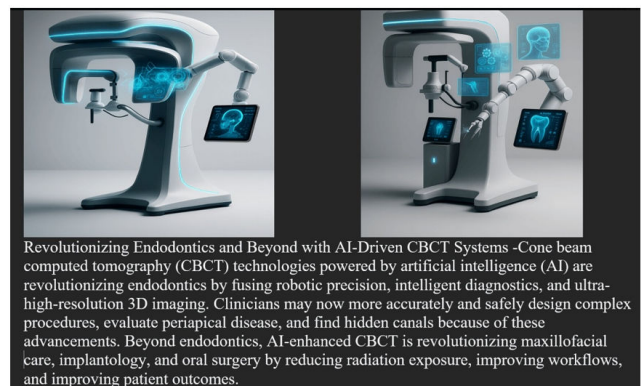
Next-Gen Endodontics: Robotic CBCT Systems in Action [44]
